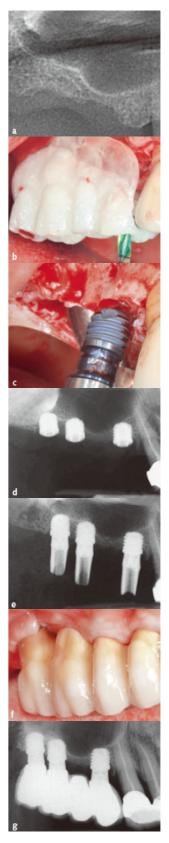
Treatment sequence of a patient with posterior maxillary edentulism randomly allocated to 5 mm short implants: a) preoperative periapical radiograph: b) a surgical stent was used to quide drilling: c) one of the 3 short implants to be placed; d) postoperative baseline periapical radiograph showing the three short implants in place: e) periapical radiograph taken at delivery of the provisional fixed dental prosthesis 4 months after implant placement; f) 4 months after initial loading the definitive fixed dental prosthesis was delivered; a) periapical radiograph taken just after delivery of the definitive fixed dental prosthesis.
